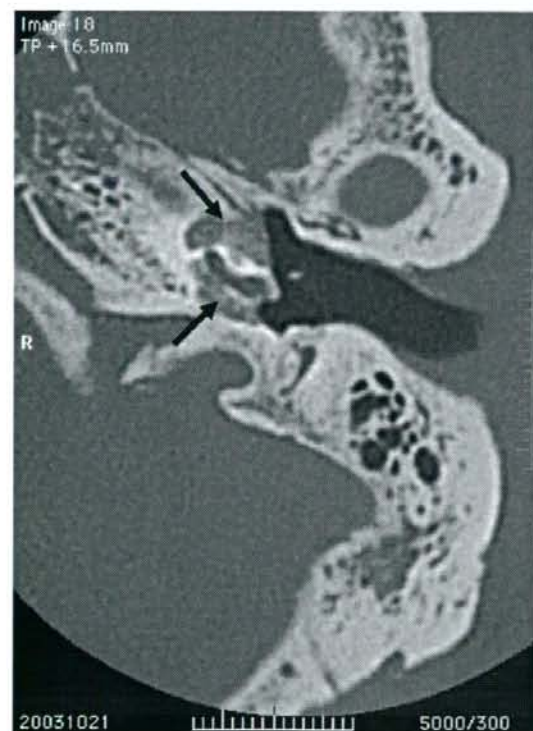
Computed tomography. This image shows severe demineralization (arrows) around the left cochlea, which is characteristic of diffuse cochlear otosclerosis.
